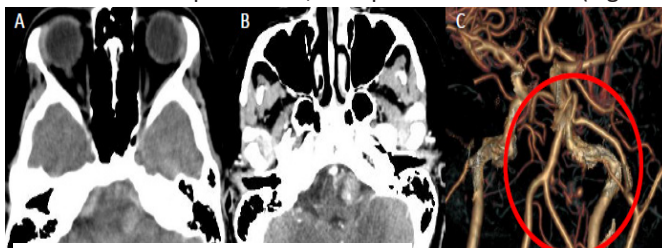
(A) Non-contrast cerebral CT in axial section showing hyperdense image in the lower left pons, compatible with a hematoma (arrow). (B) Brain CT with contrast in axial section showing a hyperdense contrast capturing lesion in the lower left pontine region (arrow). (C) AngioTEM showing vascular curl
